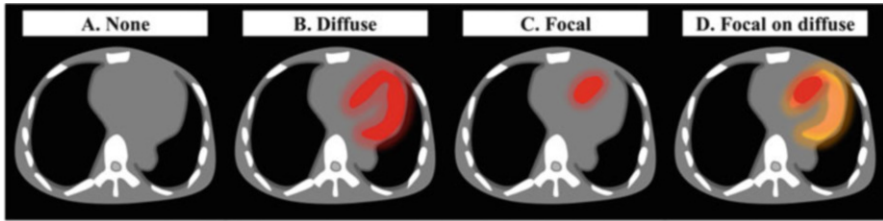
^{18}F -FDG uptake patterns to evaluate cardiac sarcoidosis.
